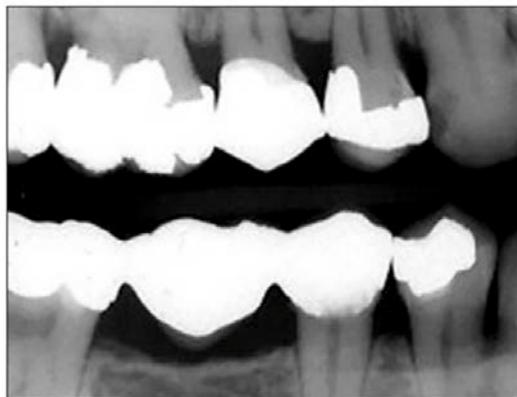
Bitewing radiograph of posterior alveolar bone crests.
